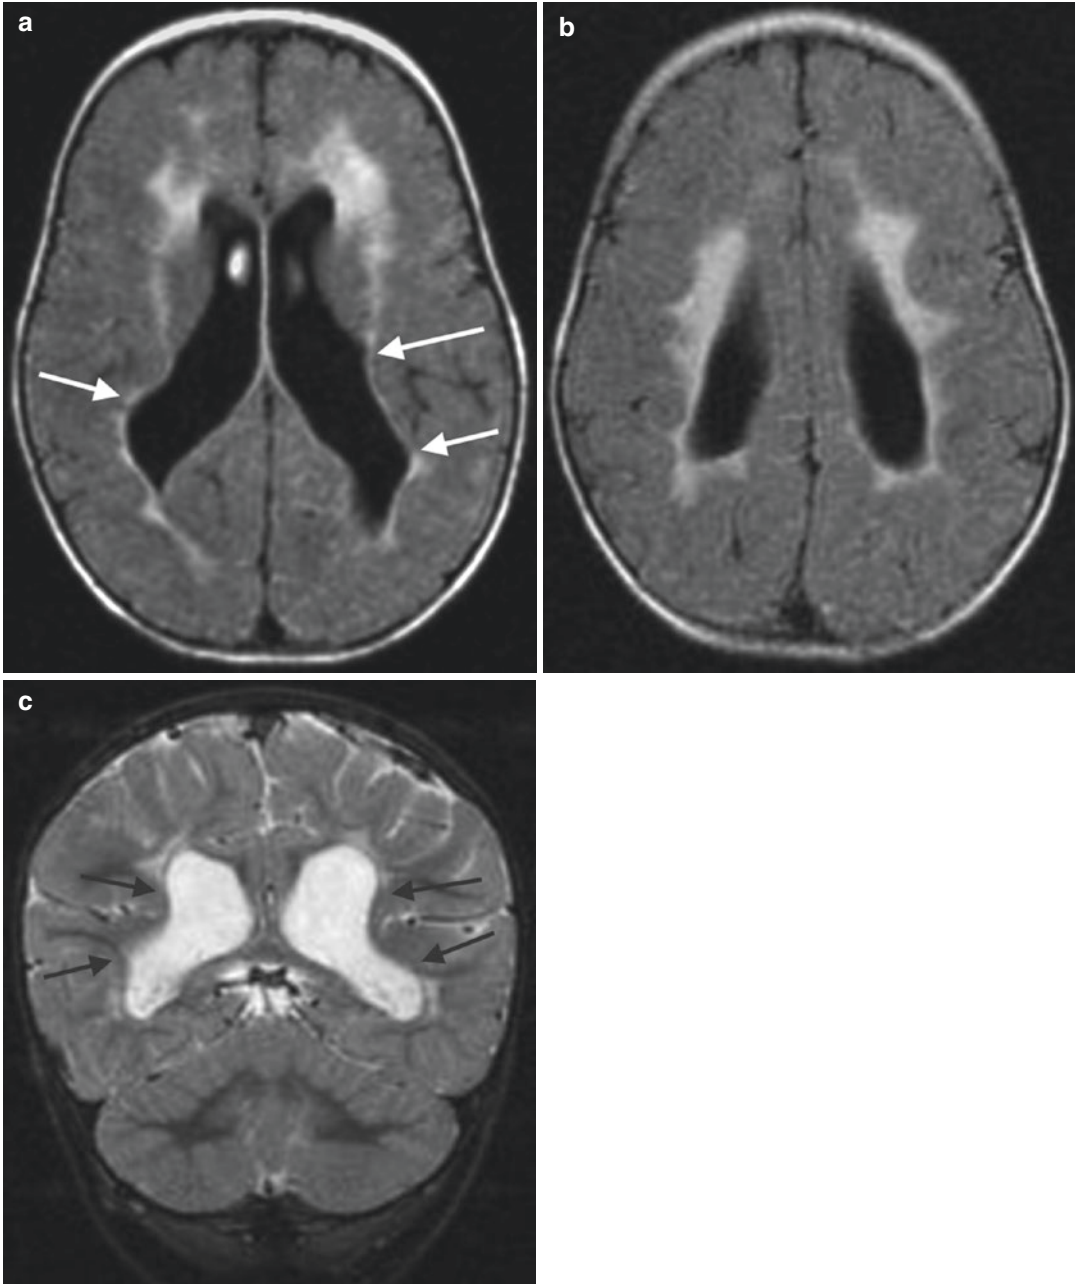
Typical findings of periventricular leukomalacia. (a) The posterior lateral ventricles are distended within undulated margin (*arrows*), there is decreased white matter volume and there is periventricular abnormal white matter signal on FLAIR imaging (a and b). (c)
